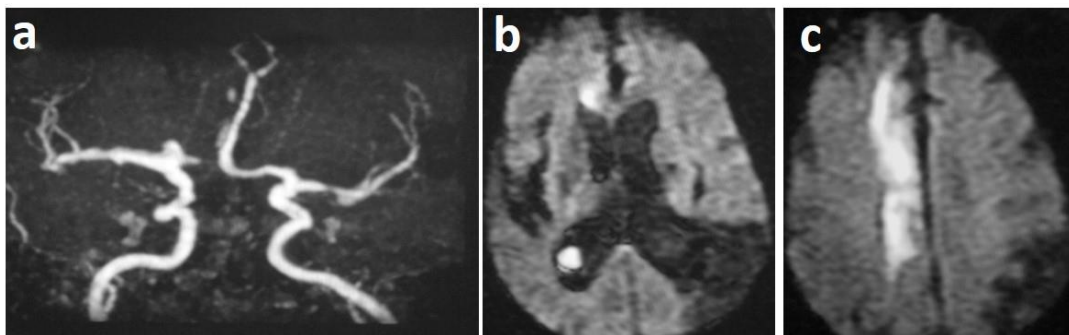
(a-c); (a) 3D TOF MRA shows thrombosis of the A1 segment of Rt. ACA, with stenosis at M1 segment of Lt. MCA. (b&c) DWI-b1000, showing acute infarction in the territory of Rt. ACA, exhibiting bright signal with old infarction in the Lt. parieto-occipital region exhibiting hypo intense signal.
